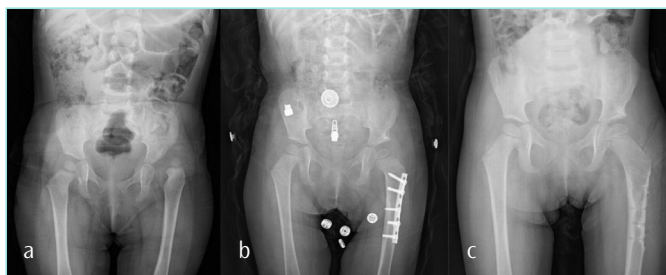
a) Pre-operative radiograph of a 19-month-old female patient with left DDH, b) postoperative 8th month radiograph of the patient who was treated with open reduction, PPO, and femoral shortening-derotation, c) 24-month radiograph of the patient with excellent results.
